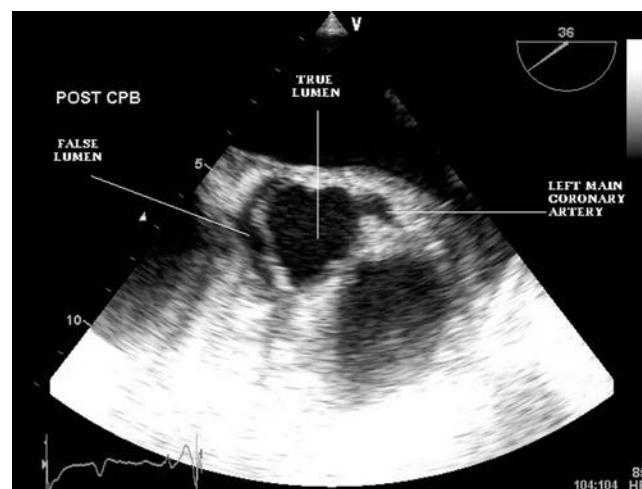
Transesophageal echocardiography of the ascending aorta just distal to the aortic valve, with an intraoperative aortic dissection evident showing true and false lumens. This dissection propagated from the antegrade cardioplegia administration site.
